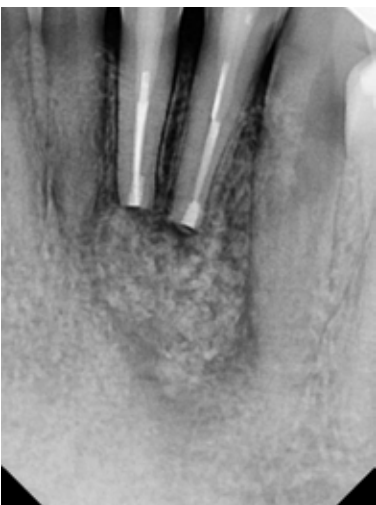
Periapical radiograph immediately following surgery to document the retrograde fillings in the two roots and the defect filled with Bond Apatite®.
